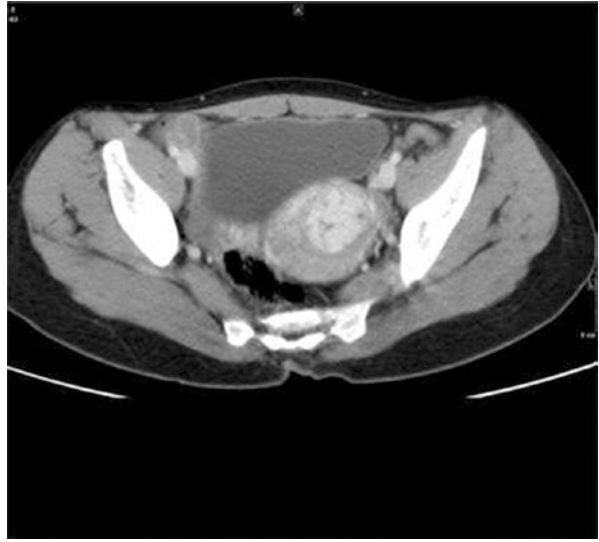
CT Abdomen images of a patient with choriocarcinoma showing extension into the parametrium with the avid enhancement of the tumor
